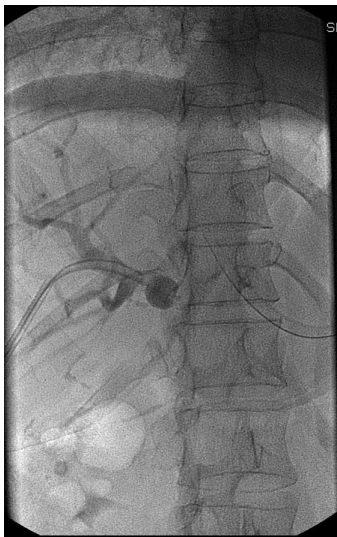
Procedure of foam sclerotherapy using polidocanol for pre-operative portal vein embolization with follow-up by abdominal dynamic CT
